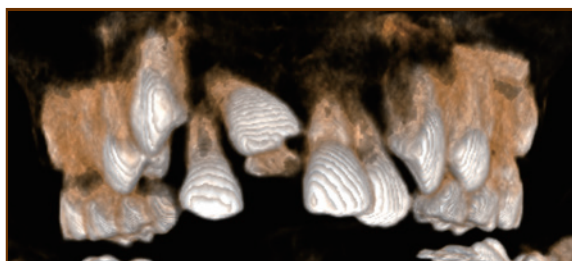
(b): Cone beam CT with supernumerary tooth and impacted upper right central incisor (Clinical picture from personal collection)
